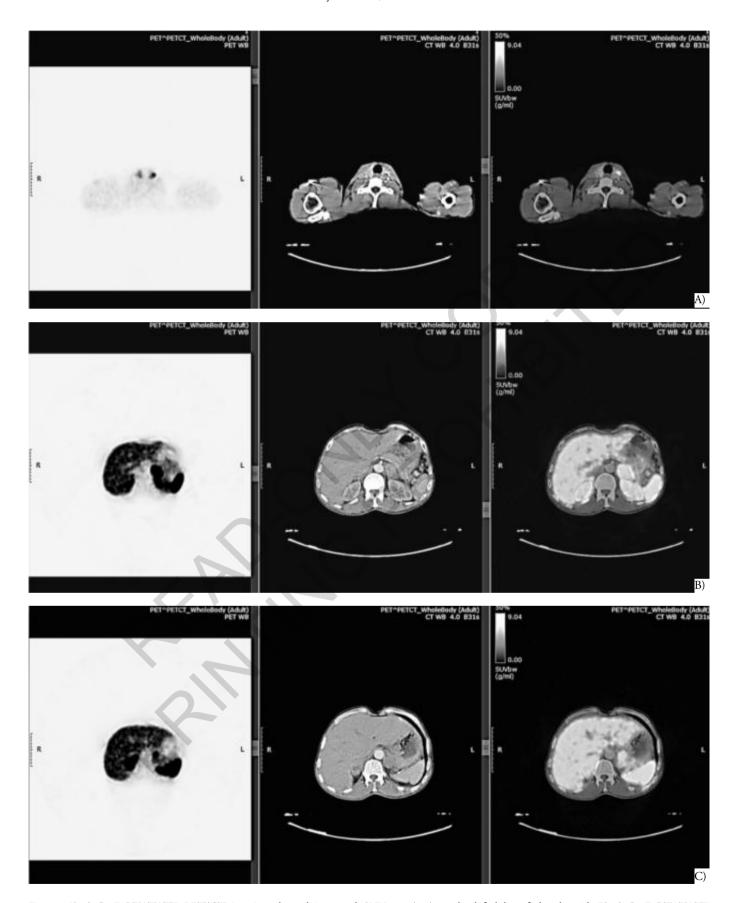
A) 68Ga-DOTATATE PET/CT imaging showed increased SUVmax (7,7) at the left lobe of the thyroid; B) 68Ga-DOTATATE PET/CT imaging showed left adrenal mass SUVmax: 32,4; C) 68Ga-DOTATATE PET/CT imaging showed right adrenal mass, SU.
